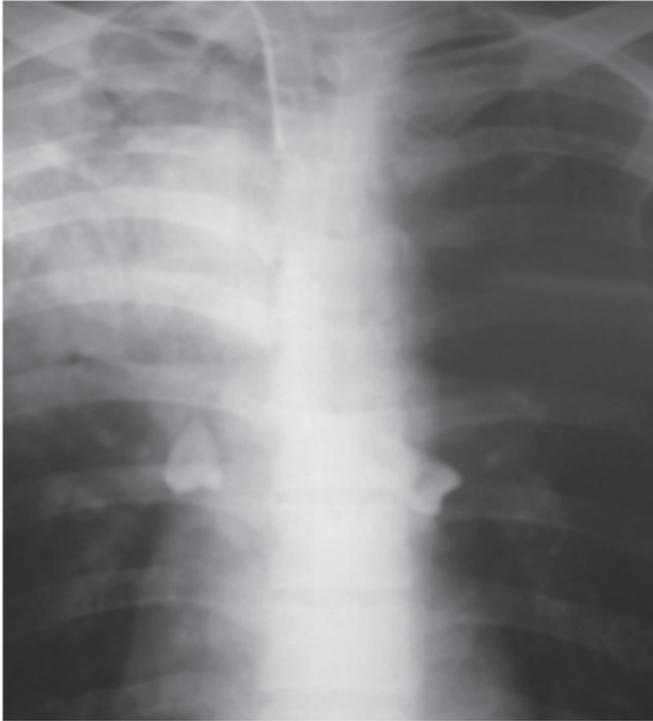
Initial chest radiograph showed one tooth in each main bronchus
